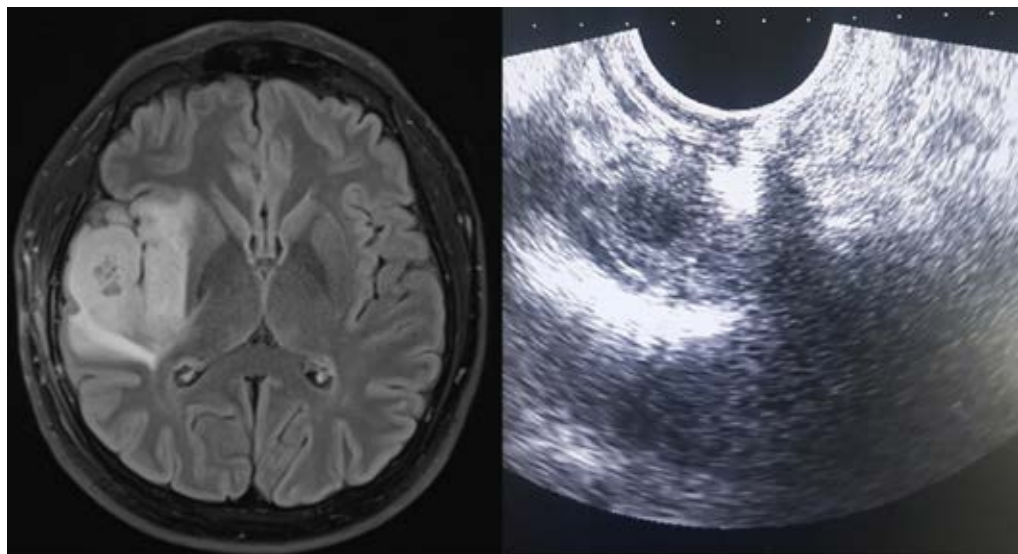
Temporal lobe diffuse-growing glioma: (A) preoperative MRI and (B) IOUS.
